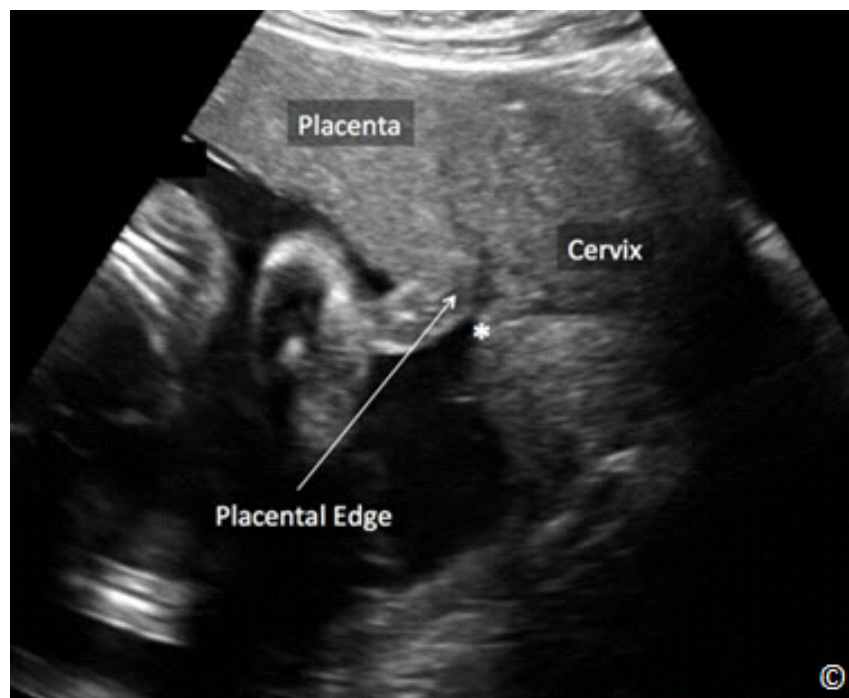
Placenta (labeled) shown on transabdominal sagittal ultrasound to be reaching the lower uterine segment, in close proximity to the cervical internal os (asterisk - labeled). A transvaginal ultrasound is indicated for accurate localization of placental edge. See text for details.
